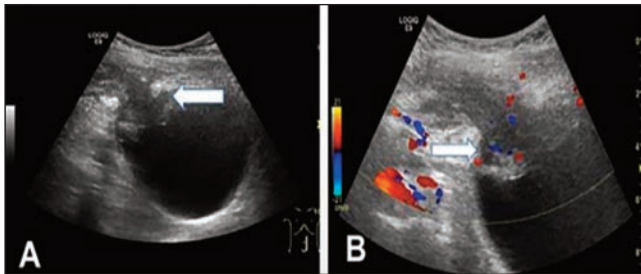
A) Two-dimensional ultrasound (2D) shows a hypoechoic heterogeneous mass (Headed arrow) in the anterior and upper part of the bladder, which is connected to the thickened bladder wall, with poorly defined borders, regular shape, and irregular liquid dark areas. B) Colour Doppler flow imaging (CDFI): dot-line blood flow signals are seen in the mass (Headed arrow), and peripheral blood flow signals are abundant.
